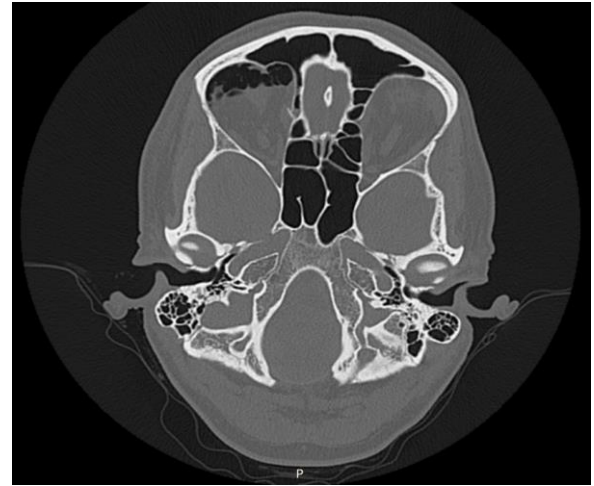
Axial view of the CT bone window showing intraorbital air on the right.
